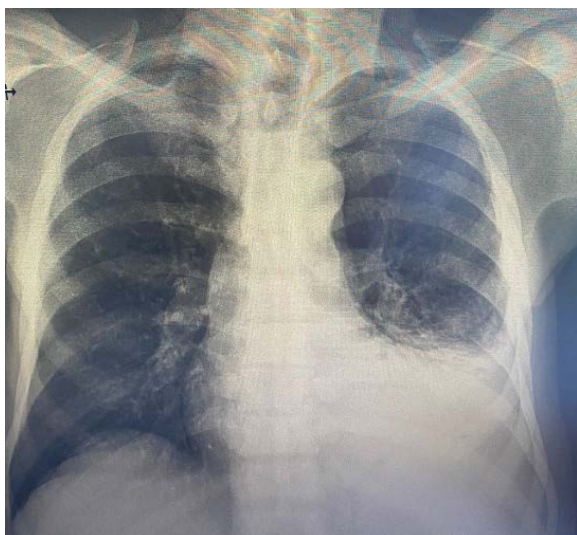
Thoracic X-ray of the chest showing fluid accumulation in the left pleural space
